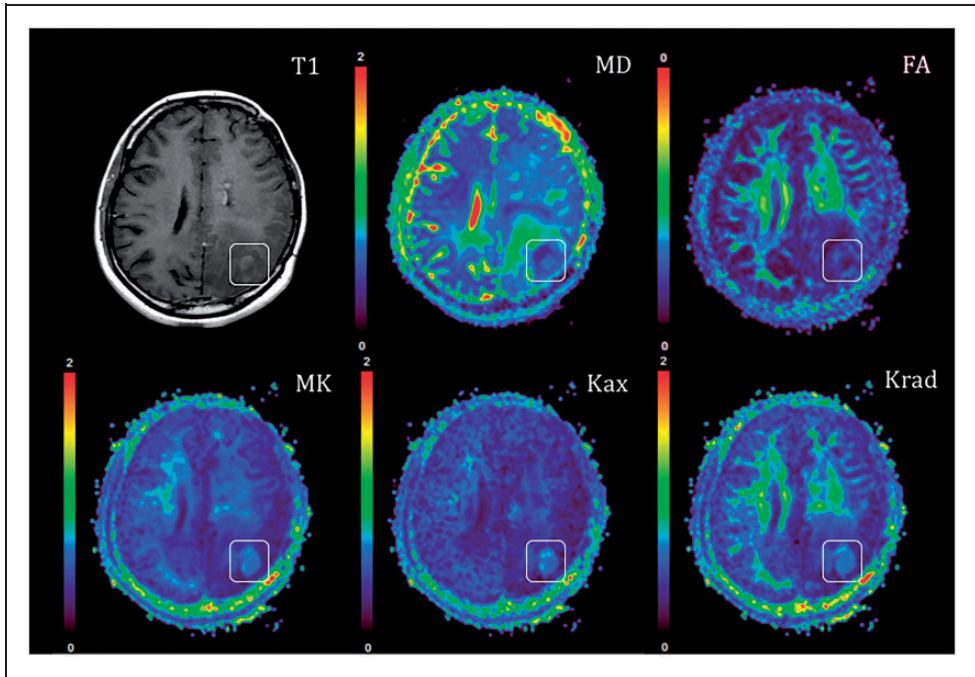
Post-contrast T1-weighted image and corresponding diffusion kurtosis parametric maps for a 36-year-old woman with WHO III glioma. The solid part of the tumor (white square) was slightly enhanced on T1-weighted image and showed different contrast on MD, FA and kurtosis parametric maps. The MD bar is shown in units of $10^{-3} \text{ mm}^2/\text{s}$, while the bars of other maps have dimensionless units.
